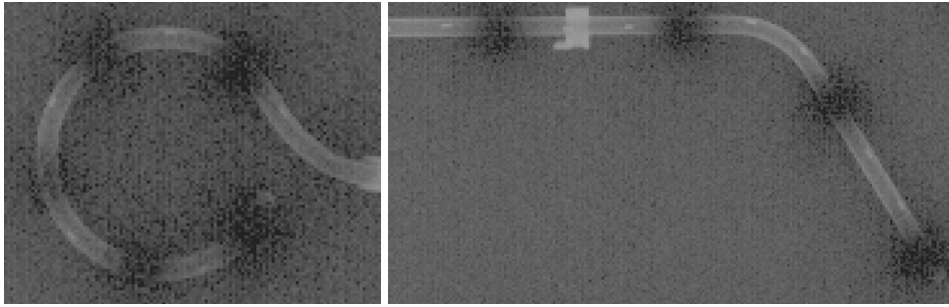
x-ray exposure. Ring and the 40 mm probe and GammaMed plus test run.
